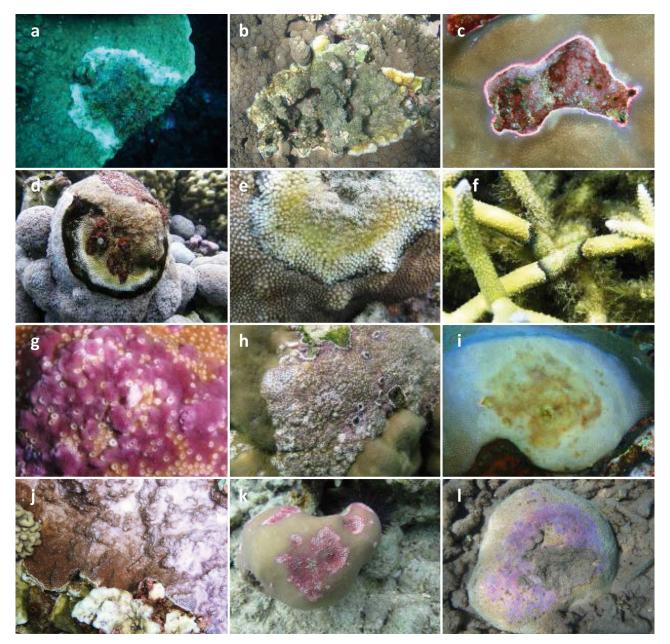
Principal coral diseases observed on 3 Western Indian Ocean reefs. White syndrome (WS) on (a) *Montipora* sp. and (b) *Acropora* sp. Pink line syndrome (PLS) on (c) *Porites lobata*. Active black band disease (BBD) on (d) *Goniopora djiboutinensis* and (e) *Hydnophora* sp. Skeleton eroding band (SEB) on (f) *A. muricata*. Growth anomalies (GA) on (g) *Astreopora* sp. and (h) *P. lobata*. *Porites* white patch syndrome (PWPS) on (i) *P. lutea*. Bleaching on (j) *Montipora* sp. Compromised tissue (CT) on (k) *P. lobata* and (l) *Astreopora* sp.
